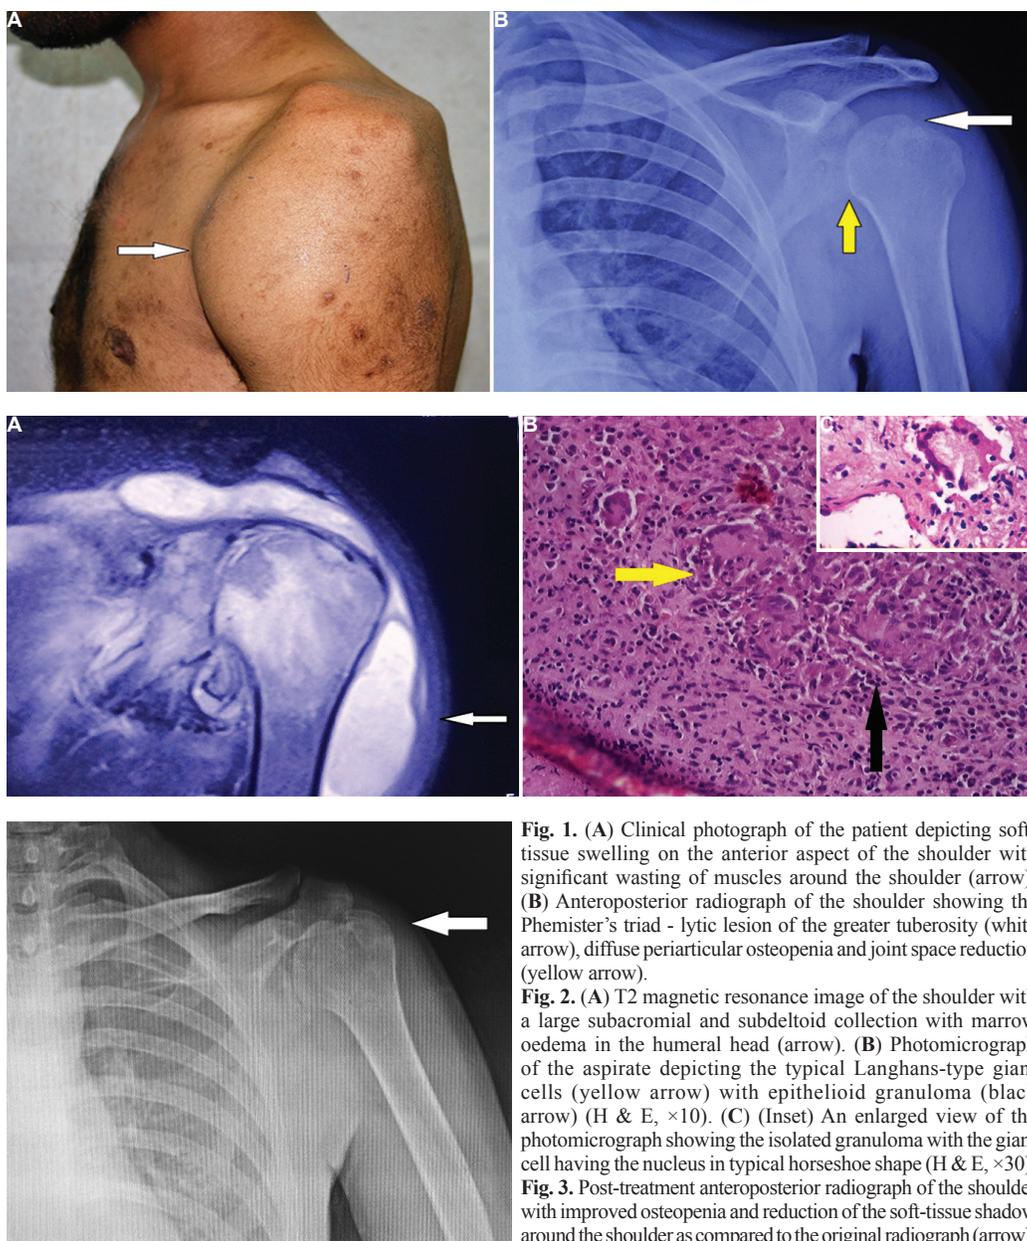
(A) Clinical photograph of the patient depicting soft-tissue swelling on the anterior aspect of the shoulder with significant wasting of muscles around the shoulder (arrow). (B) Anteroposterior radiograph of the shoulder showing the Pheemister's triad - lytic lesion of the greater tuberosity (white arrow), diffuse periarticular osteopenia and joint space reduction (yellow arrow).
